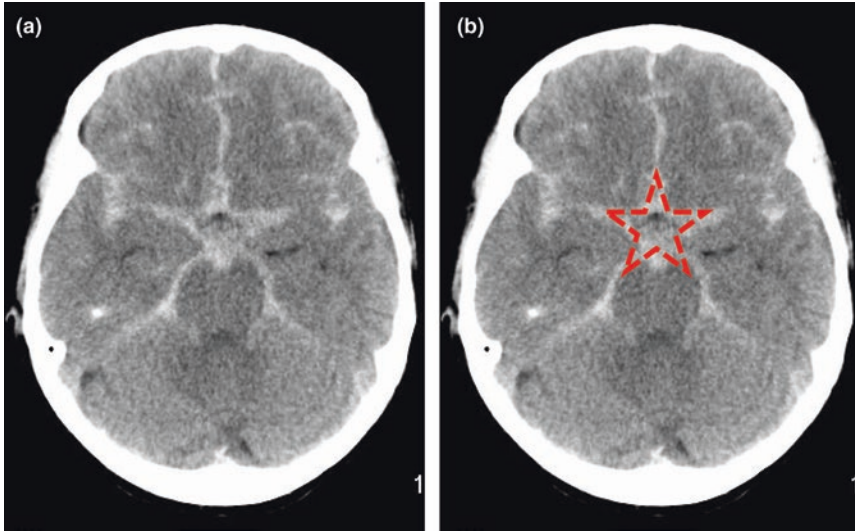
a Non-contrast CT brain performed for a 52 year old female who presented with “the worst headache of her life”. This demonstrates extensive subarachnoid haemorrhage corresponding to the five-pointed star shaped high attenuation around the circle of Willis (b)
